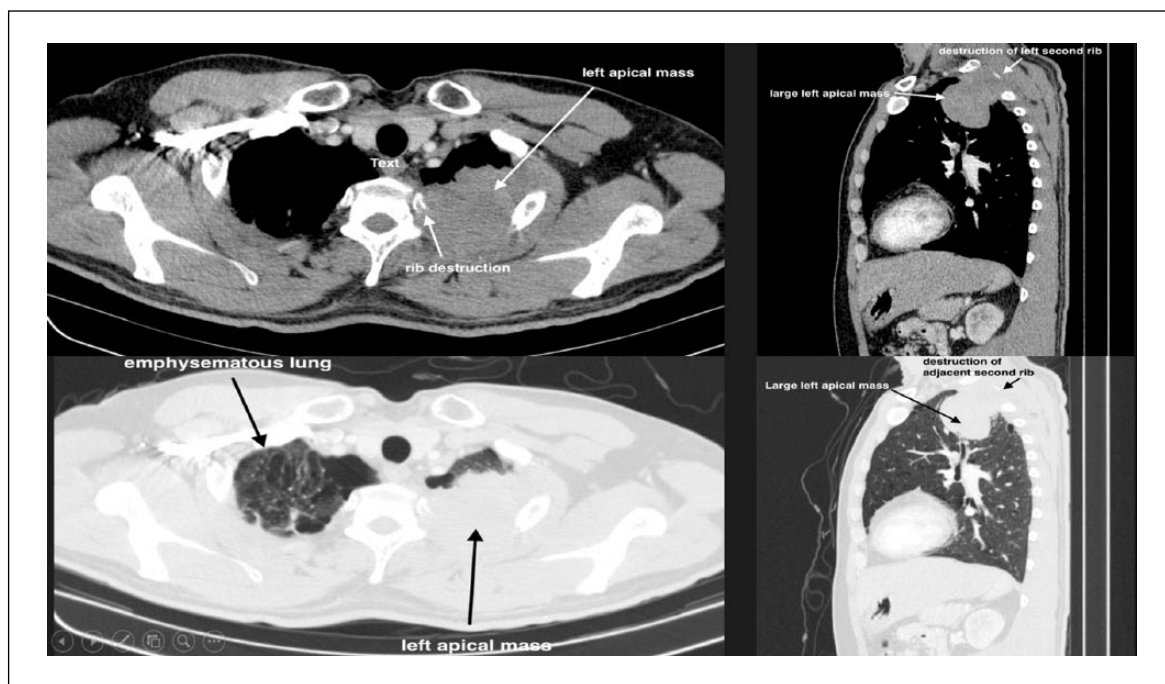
Axial and sagittal view of CT thorax, showing a left apical mass with destruction of adjacent second rib.
